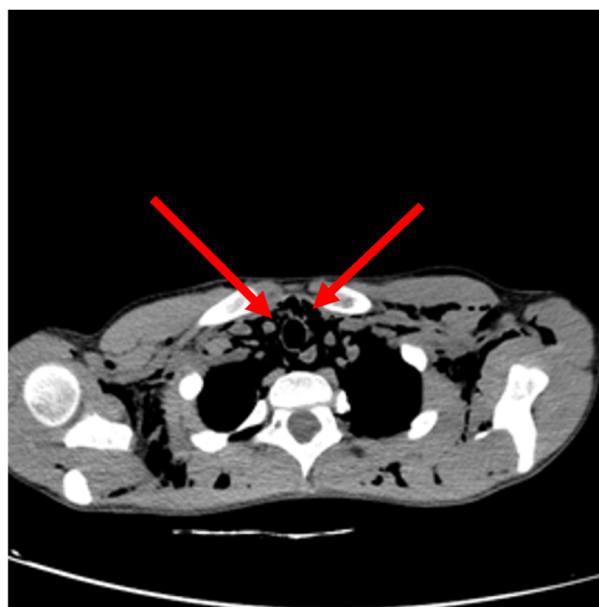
Chest CT (transverse section) showing pneumomediastinum (red arrows) with emphysema of the soft tissues of the neck and proximal thoracic wall and back.
